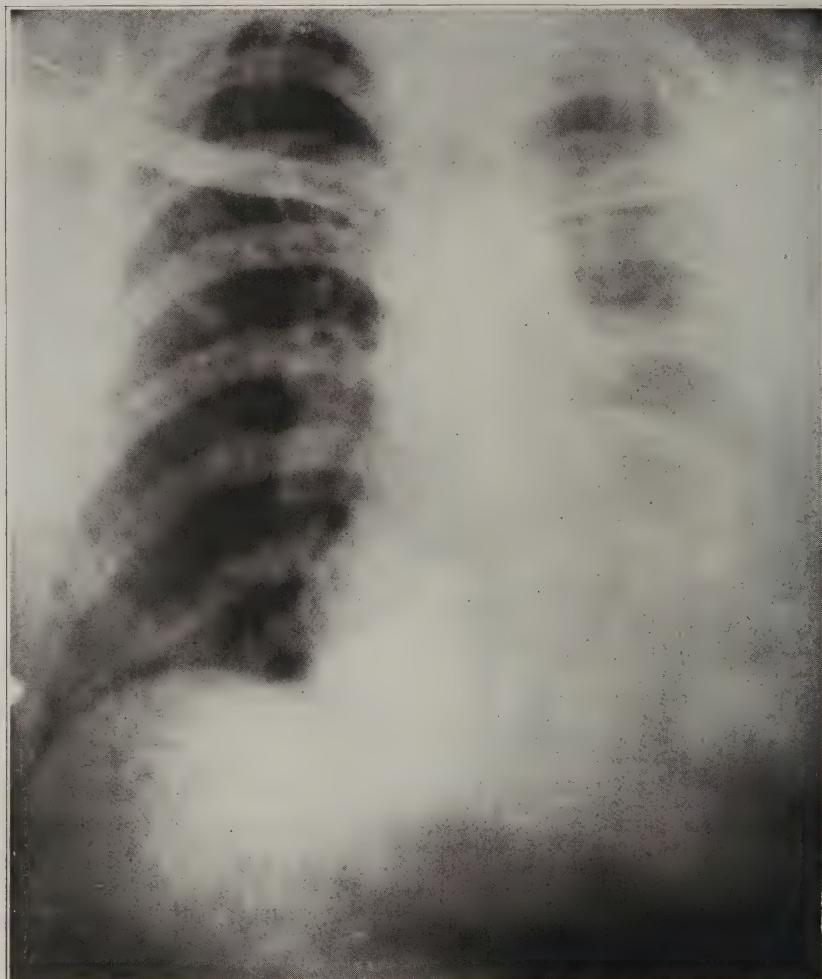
Roentgenogram (No. 14227, St. Luke's Hospital, Roentgen-Ray Department, Sept. 23, 1919) taken with the patient in the upright position.
